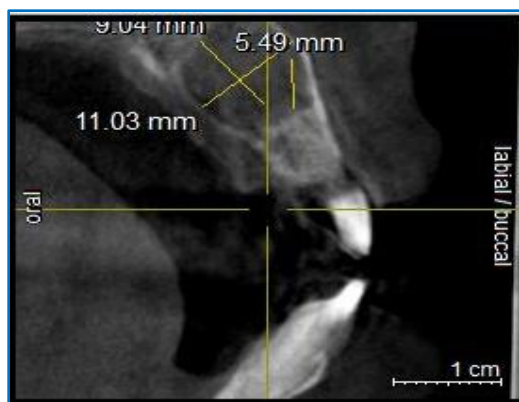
Preoperative CBCT in sagittal slice
